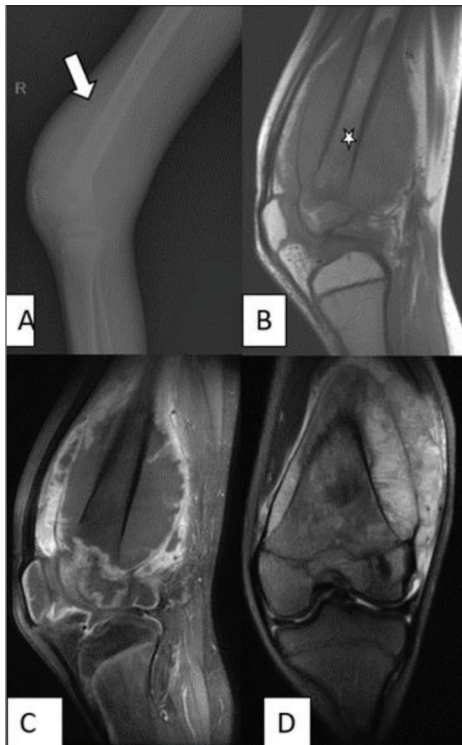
Chondroblastic osteosarcoma: A – lateral radiograph shows Codman triangle (arrow); B – sagittal T1-weighted fast spin echo magnetic resonance image of the femur intramedullary tumor extension diaphysis to epiphysis; C – postcontrast T1-weighted magnetic resonance imaging significant contrast enhancement; D – coronal T2-weighted fast spin echo magnetic resonance imaging extramedullary extension
